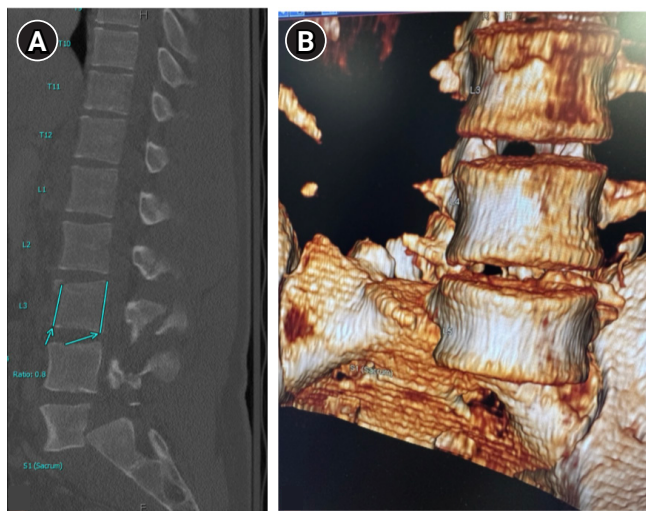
(A) Sagittal computed tomography (CT) image at the time of presentation demonstrating L3 AO Spine B2 fracture, and L5 spondyloptosis. (B) 3-D reconstruction of CT imaging demonstrating anterior inferior displacement of the L5 vertebral body over the sacrum.
